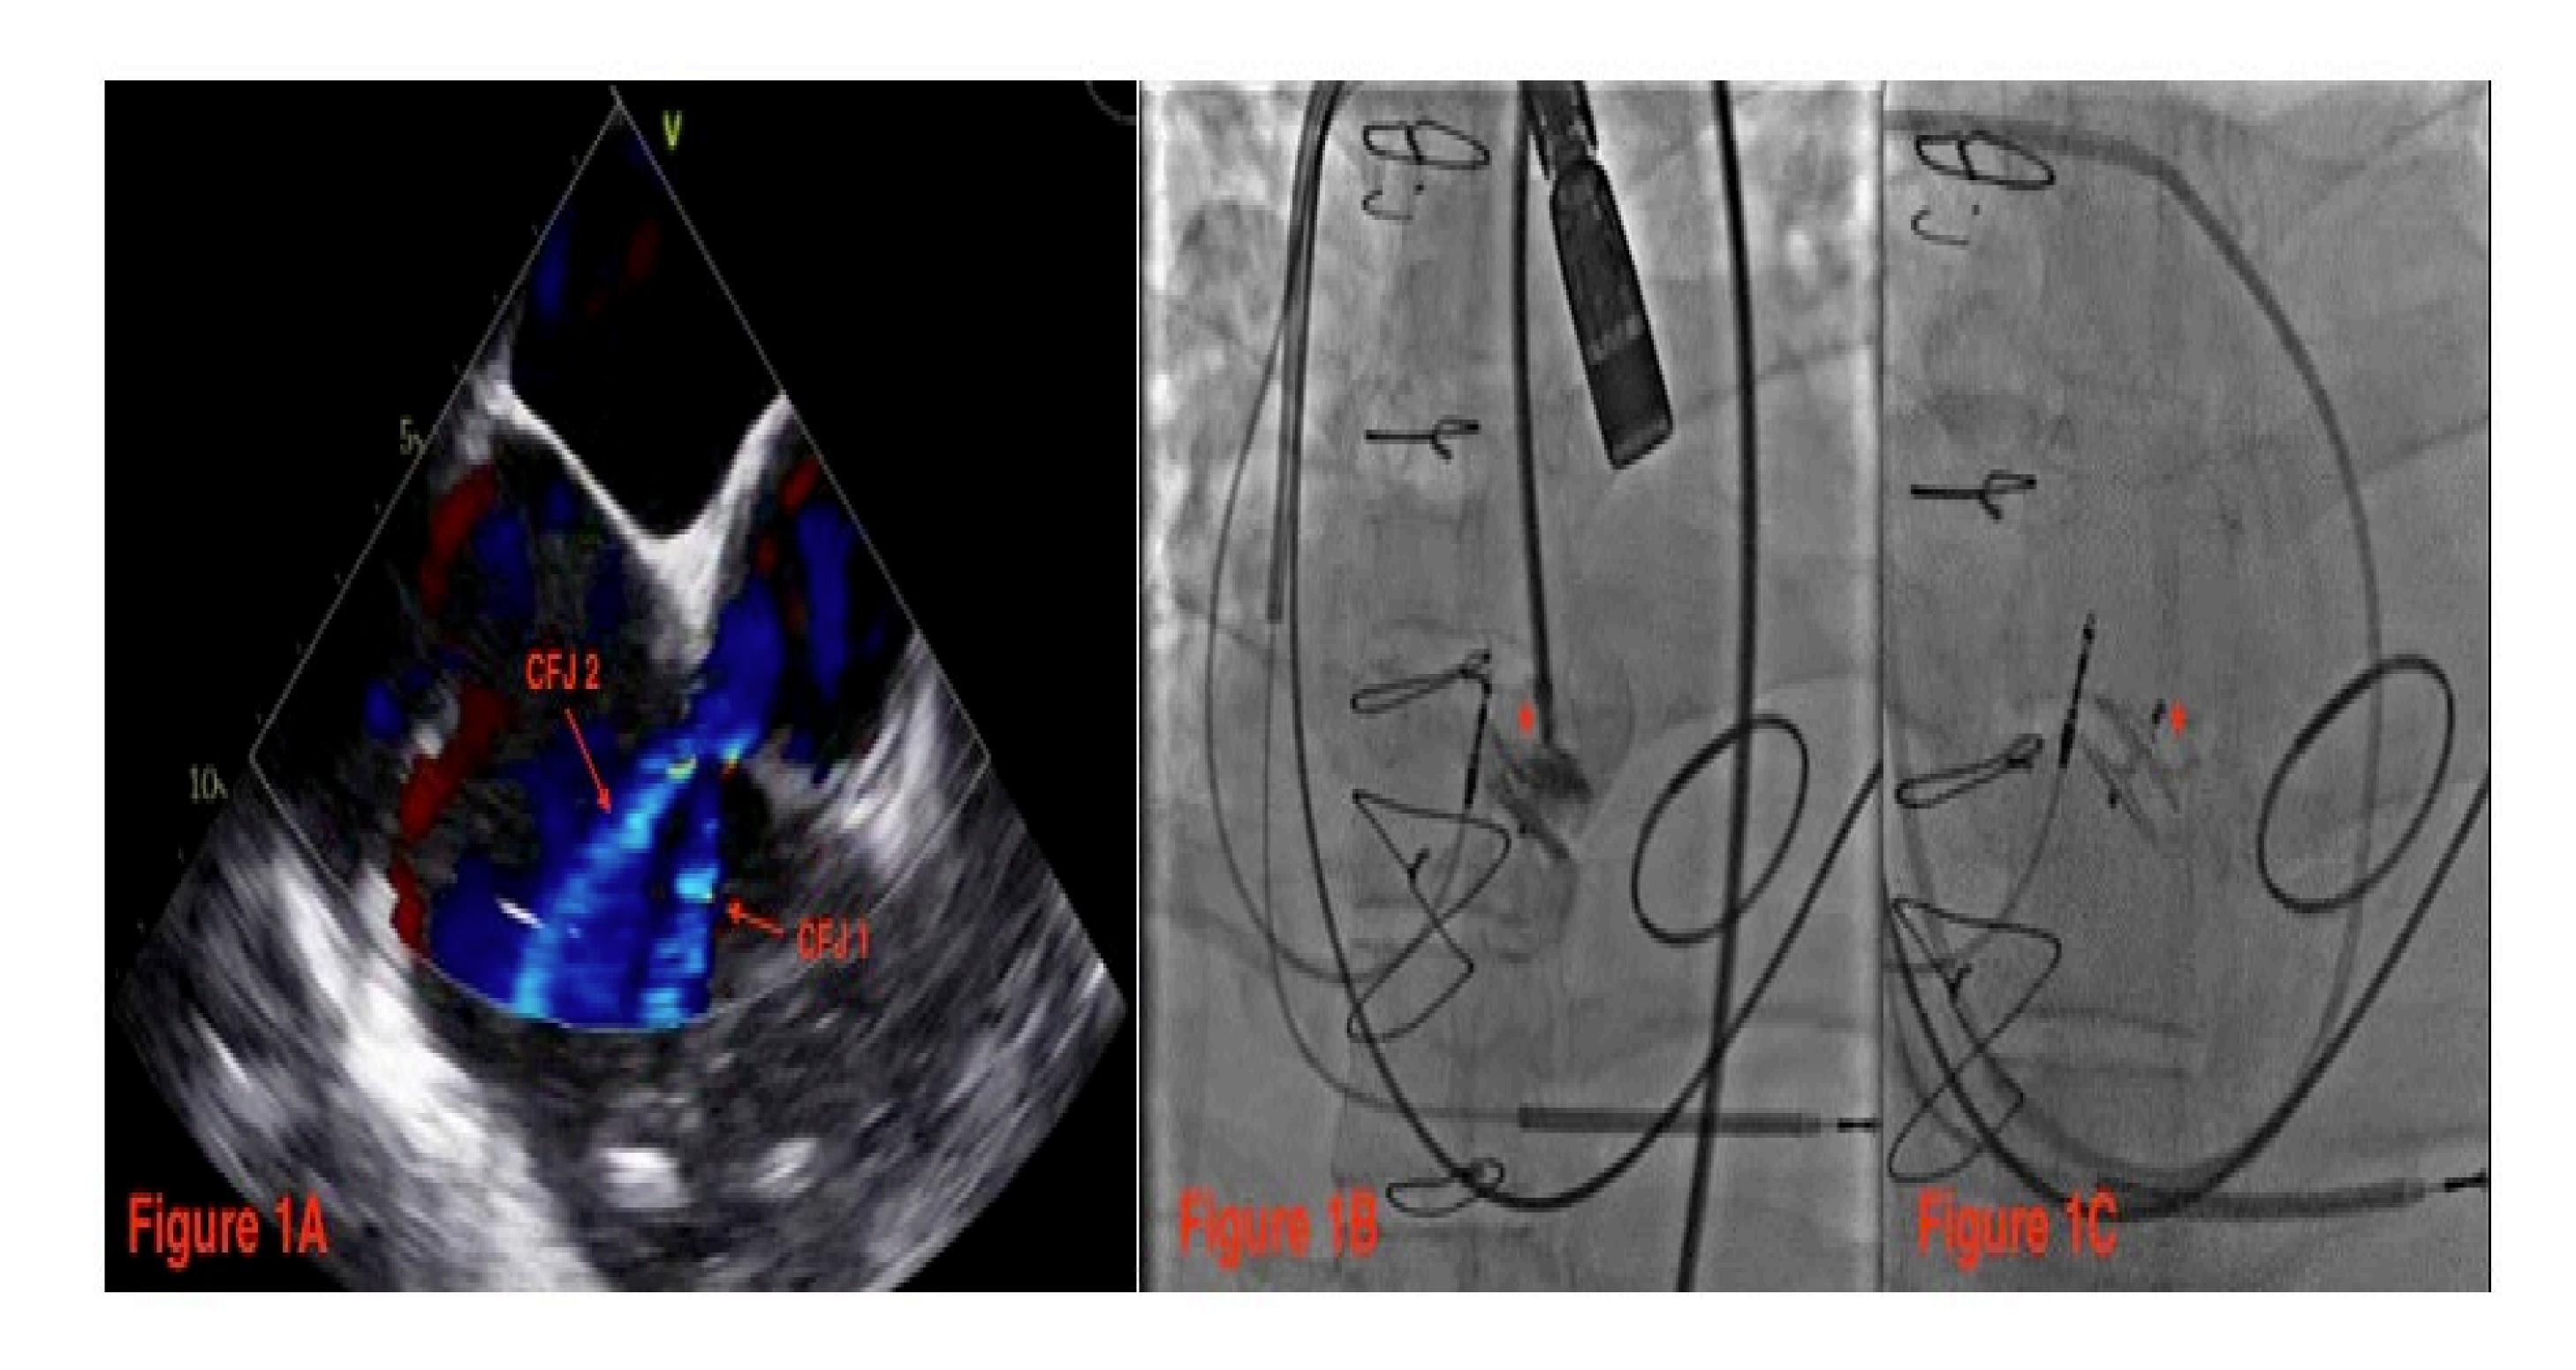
demonstrates a peri-operative transesophageal echocardiogram (TEE) with two distinct fistulae with color flow jets (CFJ1 and CFJ2) Figure 1B and Figure 1C demonstrate the successful closure of the fistulae with a closure device.
